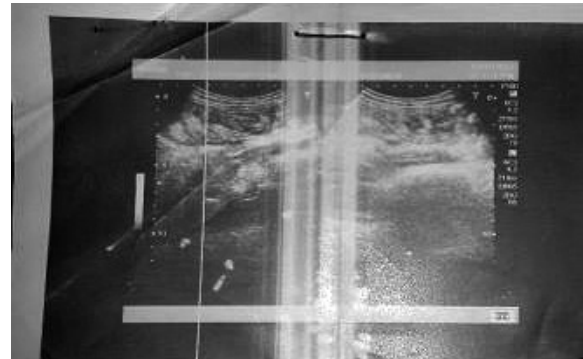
Ultrasound abdomen showing worms in the intestine
